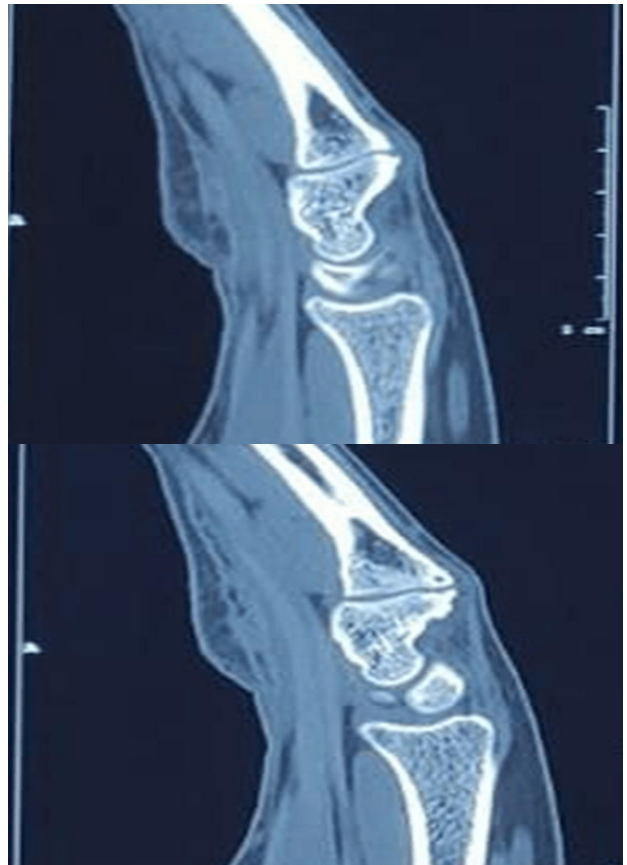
Bony outgrowth over capitate visible in CT sagittal sections.
